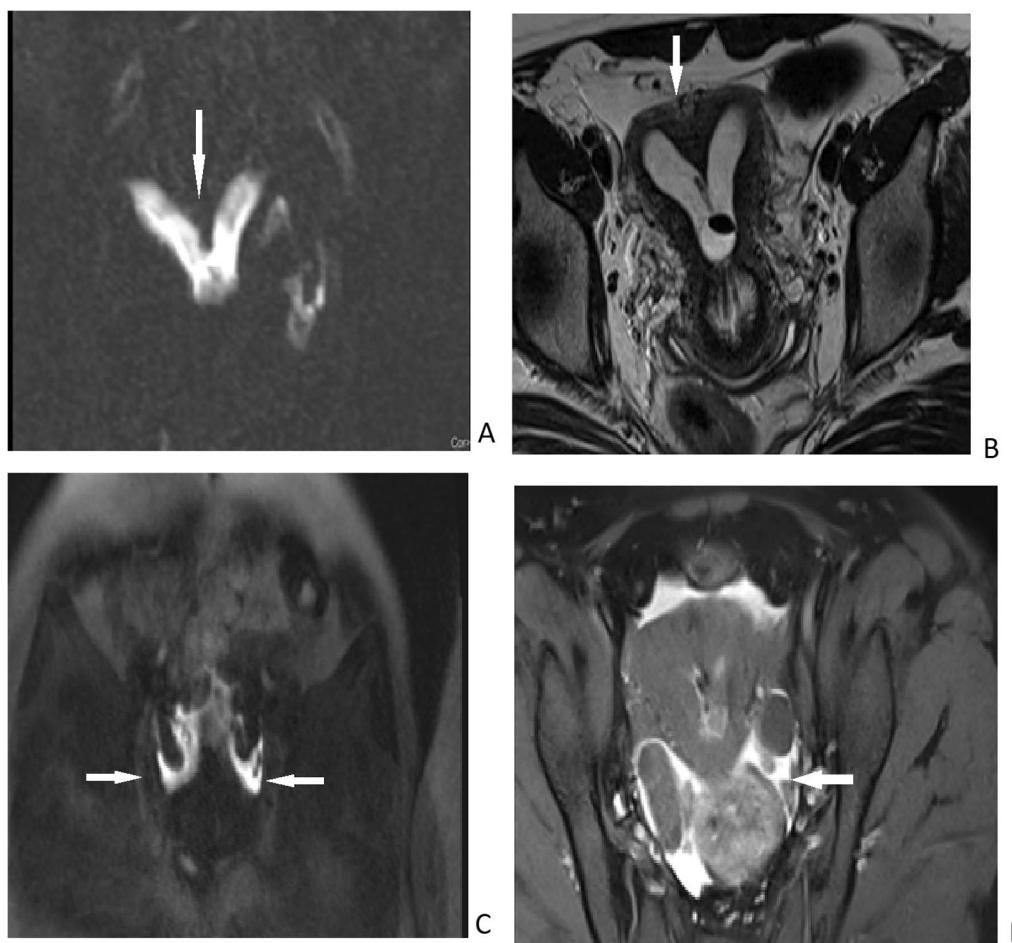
In 31-year-old woman, subtracted dynamic 3D T1-weighted angiographic (TRICKS) MR HSG image shows indentation of fundus (arrow) (A). Coronal T2-weighted image through uterus shows indentation of serosal contour of fundus, myometrium and endometrium into uterine canal, indicating septate uterus (arrow) (B). Image from subtracted dynamic 3D T1-weighted angiographic series (time-resolved imaging of contrast kinetics [TRICKS]) in 45-year-old woman shows bilateral spill of contrast material (arrows) (C). Postcontrast fat sat T1W axial image showing fluid in peritoneal cavity (arrow) (D)
